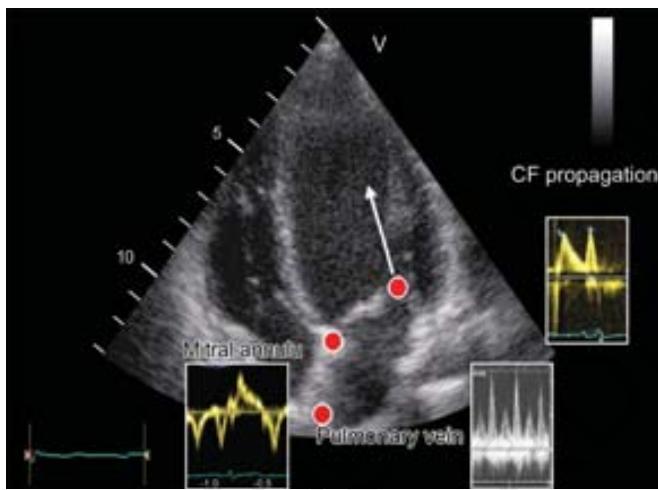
Sites for assessing diastolic function in an apical four-chamber view (4-CV).
